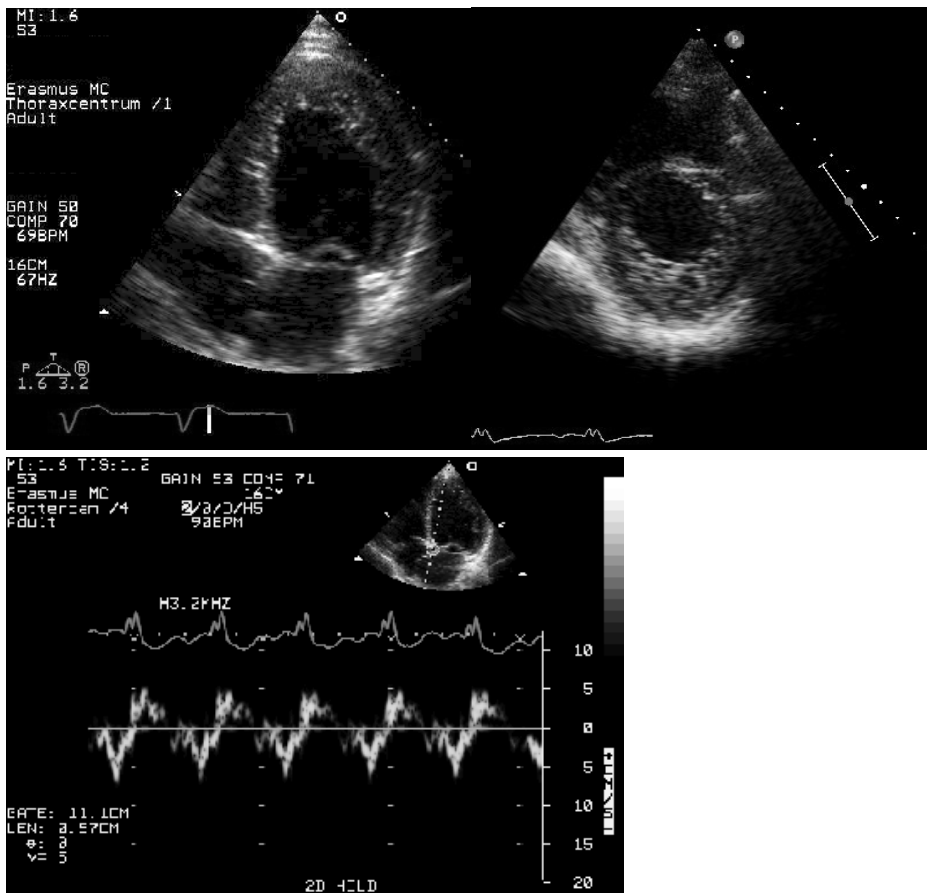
Echocardiographic features of a 58-years-old male with chronic heart failure due to familial noncompaction cardiomyopathy; (a) the apical 4-chamber view shows extensive trabeculations, especially in the apical and lateral LV walls. (b) The parasternal short axis view in end-systole, the NC/C ratio is >2 (respectively dashed line and small bar). (c) Low septal Sm (normal value 8.3 ± 1.5 cm/s).
